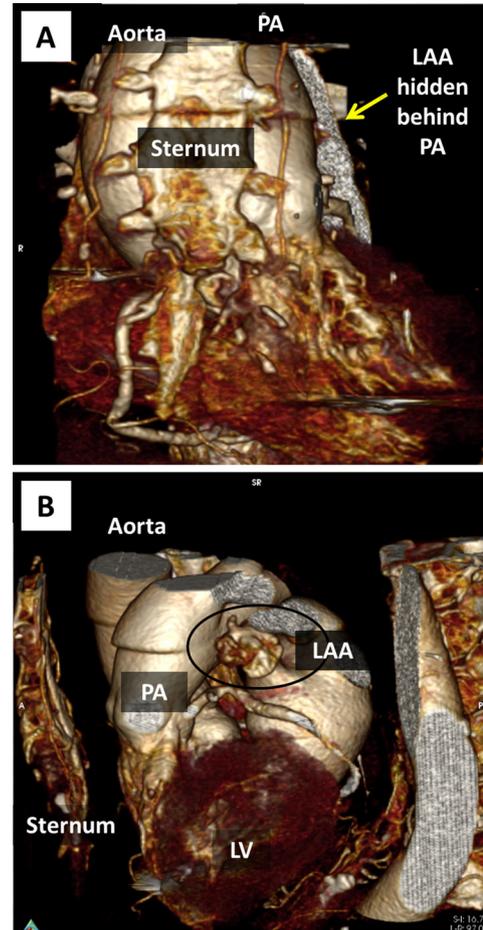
CT imaging of unfavorable LAA anatomy. (A) Anteroposterior view of the chest with the sternum in the foreground. The LAA is hidden behind the main pulmonary artery (PA). This LAA anatomy is typically unfavorable for the LARIAT procedure. (B) Corresponding lateral view with the LAA in the foreground and posterior to the PA. LV, Left ventricle.
